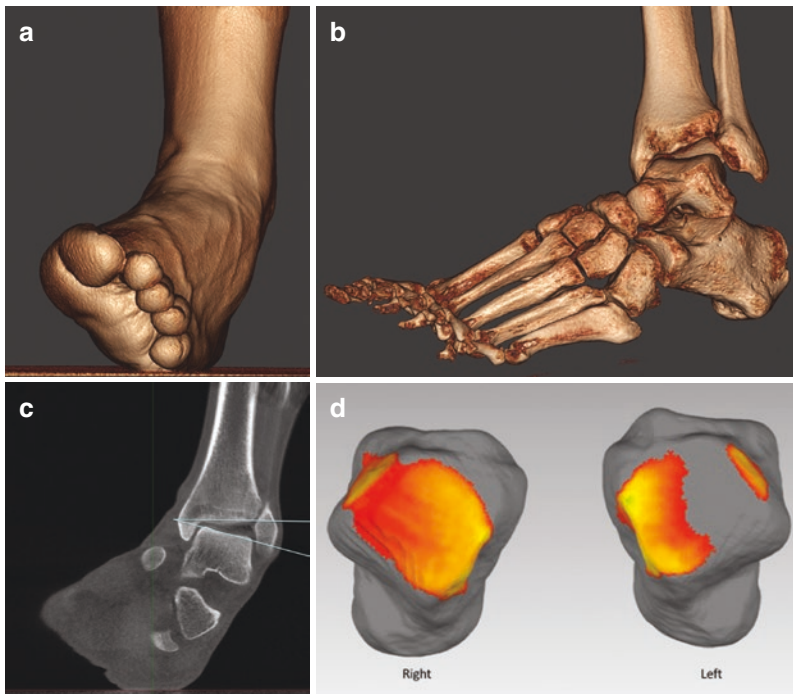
Demonstrates the possibility in a large field of view cone beam WBCT to investigate dynamic postures such as varus in this case of chronic lateral ankle instability. An important intra-articular lateral talar tilt can be visualized and measured. The subtalar joint may be investigated in the MPR windows (c) or on the 3D rendering view (a, b). A distance mapping view (d, image courtesy of Pr Sorin Siegler, Drexel University, Philadelphia PA, USA) may be built from the harvested data. In this case the right side demonstrates good joint congruency, whereas the left side demonstrates approximation in the medial aspect of the tibiotalar joint and important distancing in the lateral aspect of the joint
